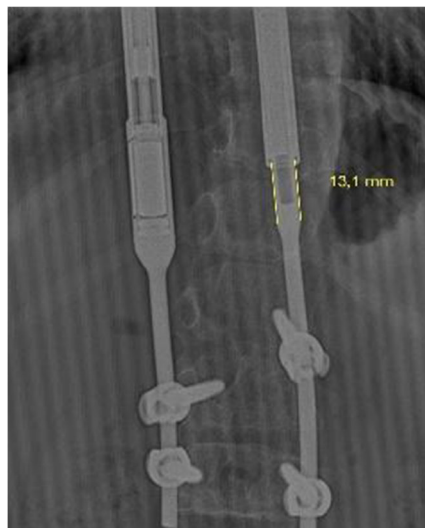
Plain radiograph (AP projection) of the same patient as in Fig.1, at the same time. The corresponding measured segment is highlighted by the yellow line.
